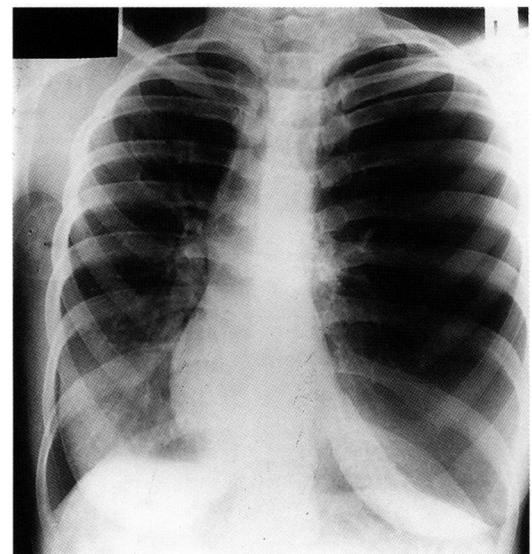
Chest radiograph at presentation showing hyperlucent left upper lobe with mediastinal shift toward the right.
